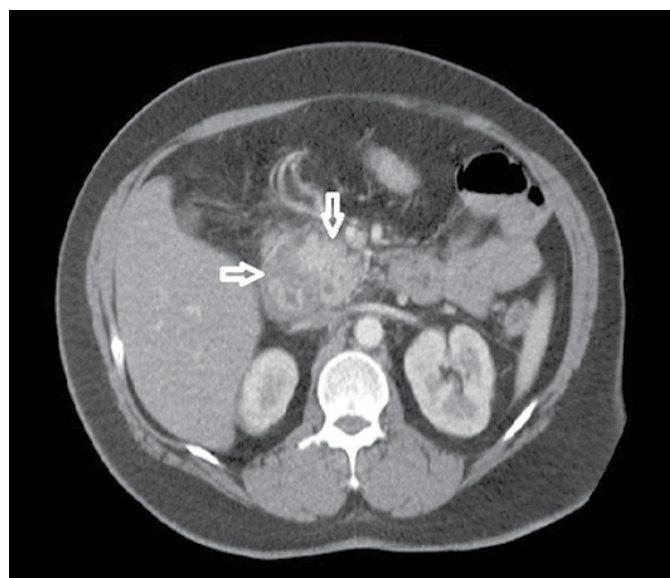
A contrast enhanced computed tomography scan of the abdomen showing swelling of the pancreatic uncinate, thickening of the distal segment of the second part and proximal segment of third part of the duodenum.
